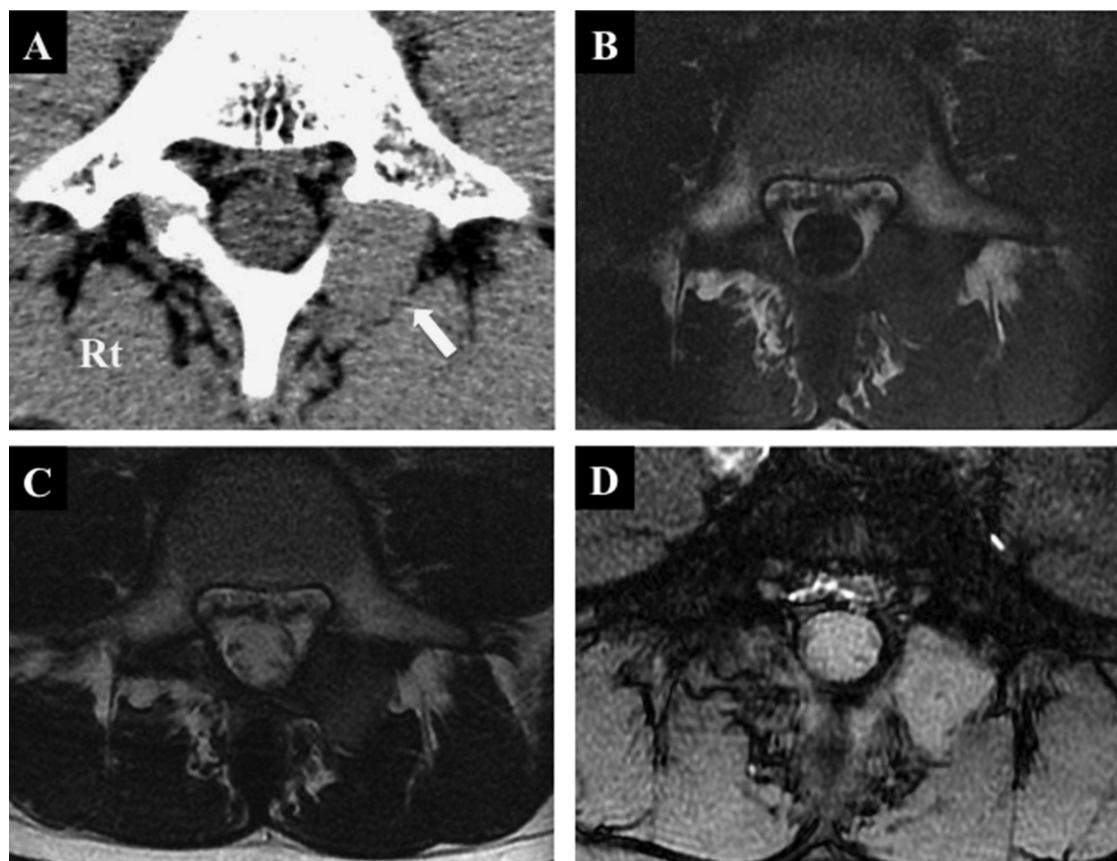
A 1 × 2-cm tumorous mass located on the left pars defect at L5, slightly eroding the L5 lamina. The mass presented with intermediate intensity on T1-weighted images (WIs) and high intensity on T2-WI and T2 STAR-WI. Axial computed tomographic scan (A), T1-WI (axial view) (B), T2-WI (axial view) (C), and T2 STAR-WI (axial view) (D). The arrows shows tumor mass.
